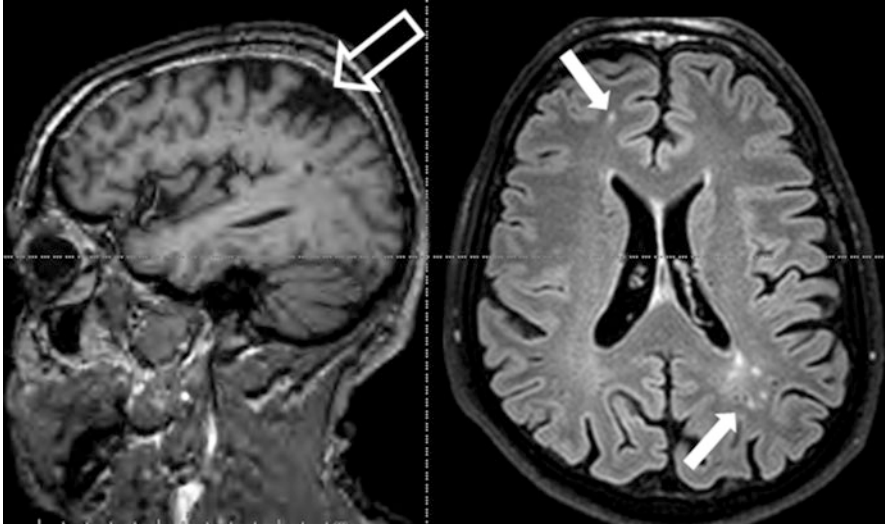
Left panel: T1-weighted sagittal image showing moderate atrophy in the parietal lobe (empty arrow). Transverse Flair image showing white matter hyperintensities more prominent in the left posterior hemisphere, but visible also in the right frontal subcortical regions (full arrows)
